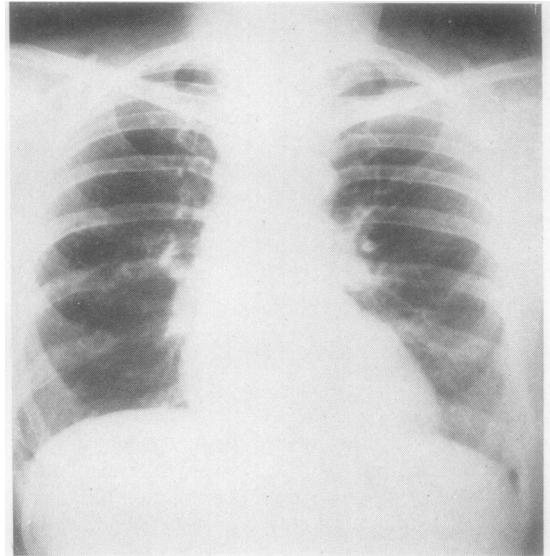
Case 2, February, 1956. Postero-anterior and right lateral radiographs showing resolution.
